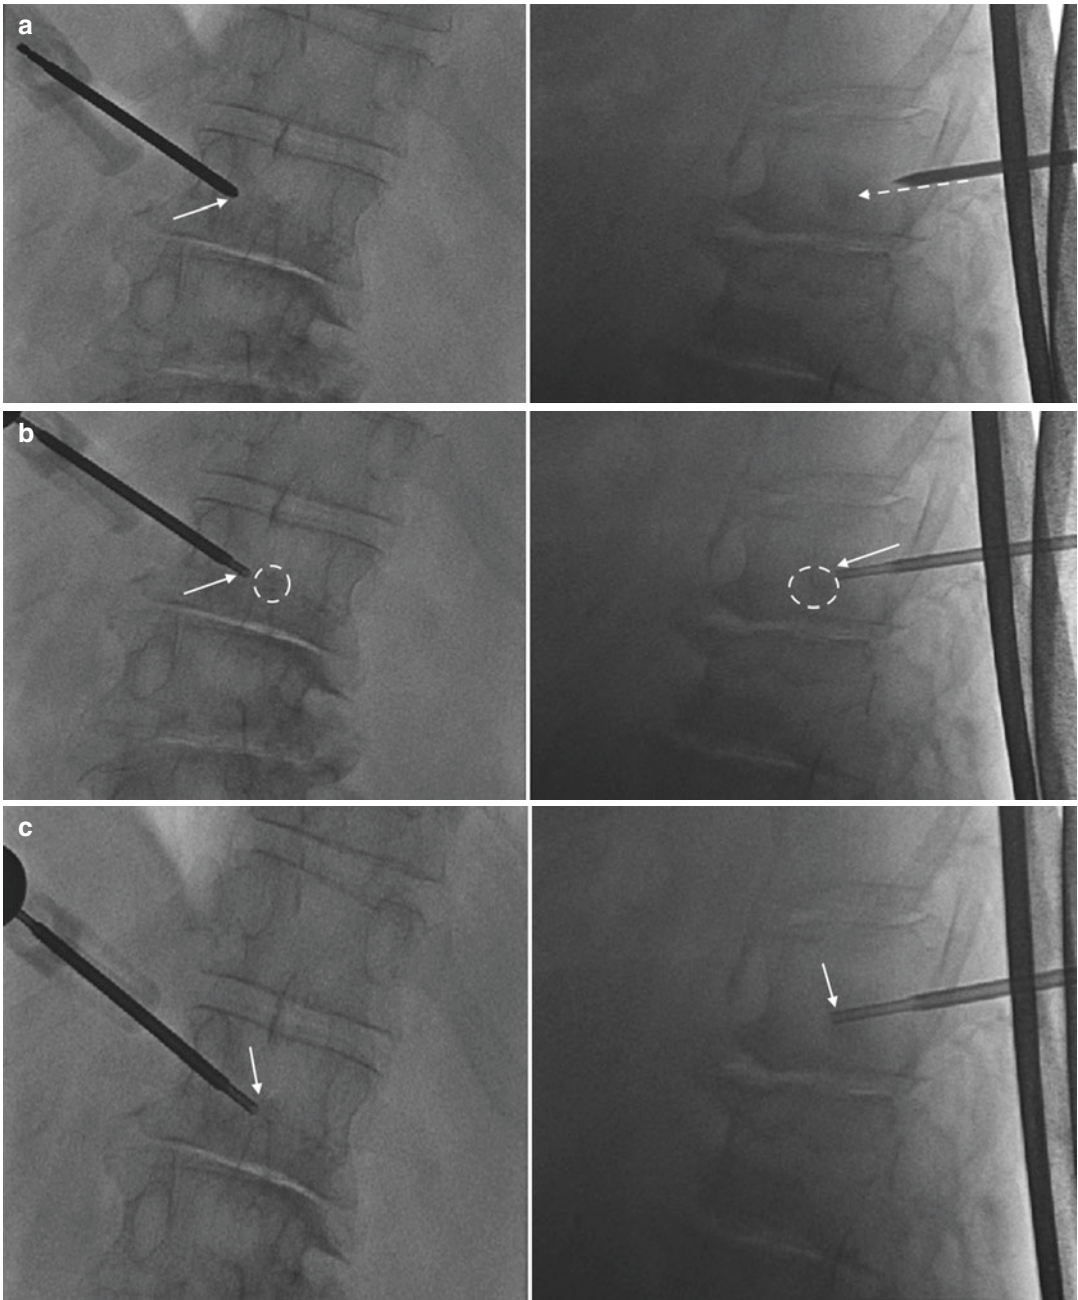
An 83-year-old female with breast cancer and thyroid cancer and an L1 bone lesion on an MRI examination. Frontal and lateral fluoroscopic images (a) show transpedicular placement of a bone needle. Frontal and lateral fluoroscopic images (b) show coaxial insertion of a
